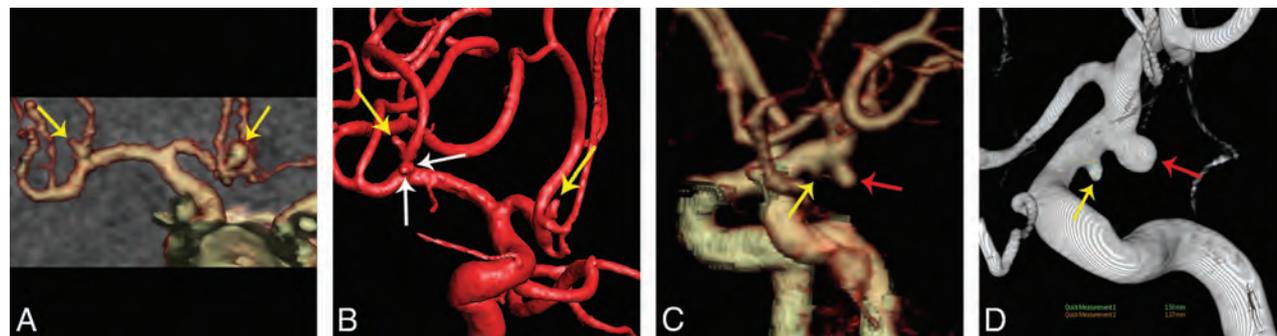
False-negative aneurysms in the 2 CTA protocols. *A* and *B*, An 80-kVp cerebral CTA with 30 mL of contrast agent in a 50-year-old man. *A* volume-rendered digital subtraction CTA image (*A*) shows 2 true-positive aneurysms in the anterior communicating artery and right middle cerebral artery, respectively (yellow arrows), while another 2 small aneurysms with diameters of 1.1 and 0.6 mm were found in the right middle cerebral artery (white arrows) on 3D-DSA (*B*), which were not found in the CTA image. *C* and *D*, A 120-kVp cerebral CTA with 60 mL of contrast agent in a 46-year-old man. The volume-rendered digital subtraction CTA image (*C*) shows a true-positive aneurysm in the left anterior choroidal artery (red arrow) and a false-negative aneurysm in the left posterior communicating artery (yellow arrow). The aneurysm in the left posterior communicating artery (yellow arrow) was found at repeat interpretation. 3D-DSA shows the 2 aneurysms (*D*).
